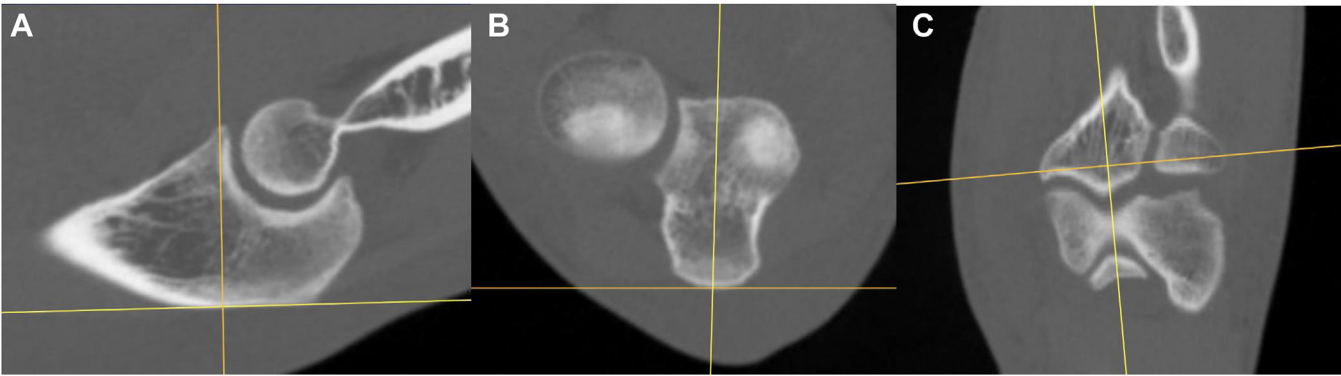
Computed tomography sections showing how perpendicular lines relative to the dorsal cortex of the ulna (A), the flat dorsal surface of the proximal ulna (B), and the plane through the coronoid and olecranon apices (C) were used as standardized references for axis reorientation.
